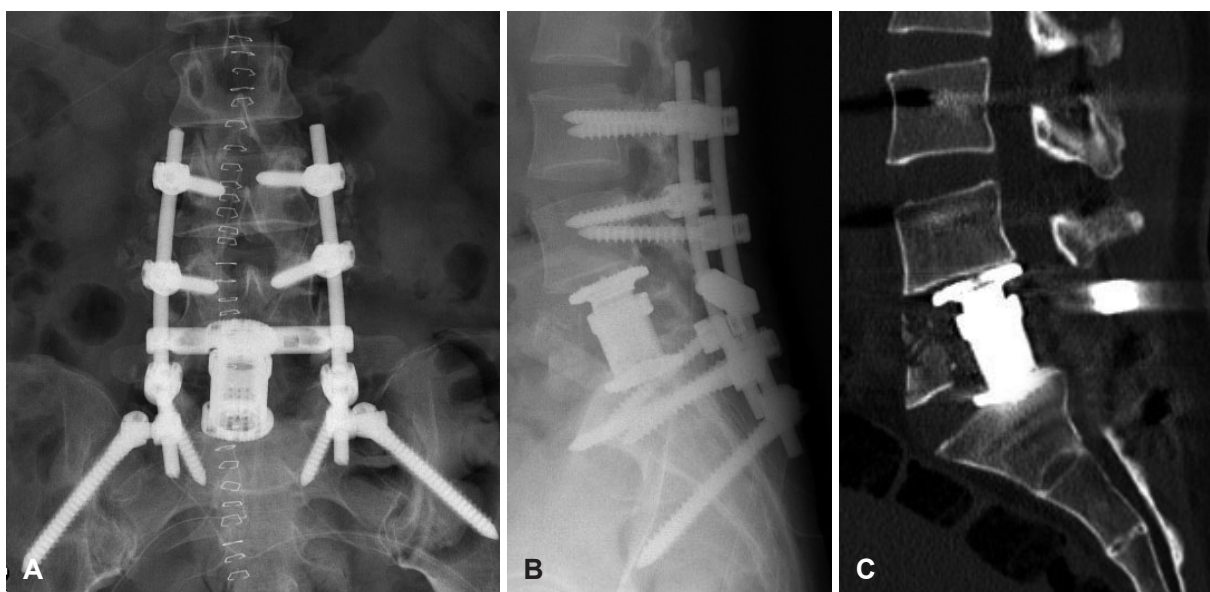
A: AP view after stabilization L4-S1-alar screw and Synex expandable cage. B: Lateral view after stabilization. C: CT scan 1 year after operation (sagittal reconstruction) shows fully decompressed canal and the presence of fused anterior reconstruction.
